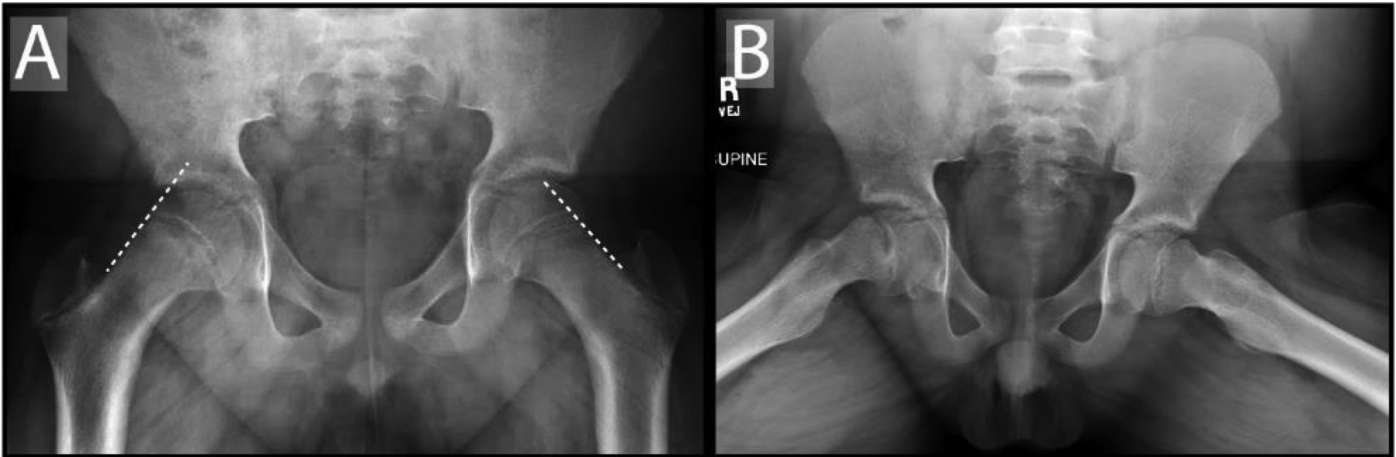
Anterior-posterior (AP) and frog lateral radiographs of an 11-year-old male with stable right SCFE. (A) AP view demonstrates that Klein's line, a line parallel to the femoral neck at its superior border (white dashed line), intersects less epiphysis on the right, affected side. (B) Frog lateral view demonstrates physeal widening and relative posterior displacement of the right capital femoral epiphysis on the metaphysis.
